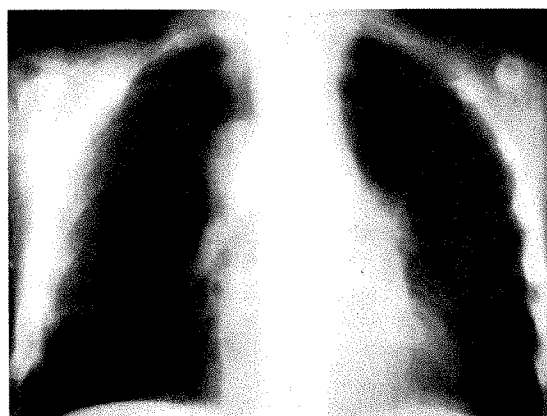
Case IV. Posteroanterior roentgenogram of the chest showing a mass in the right paraspinal area.
